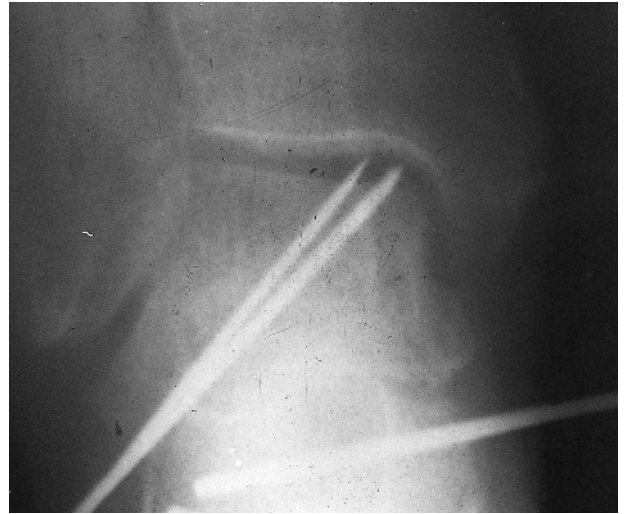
Anteroposterior radiograph of the ankle seen in Figures 7.61 and 7.62 demonstrates placement of the two pins into the posteromedial talar dome lesion.
